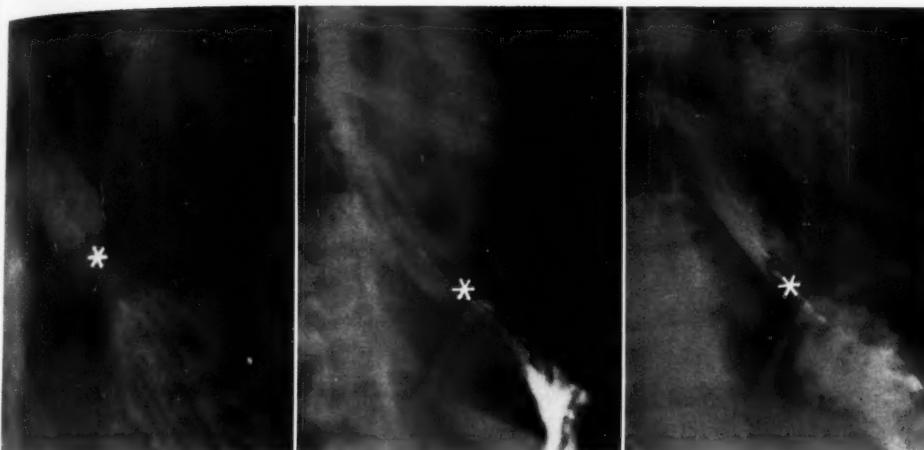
Relationship of PIP (star), as determined by intraluminal pressure tracings, to the roentgen appearance of the terminal esophagus and esophagogastric region in 3 normal cases during drinking of fluid barium. The patients are lying in the right anterior oblique position. No command to suspend respiration was given. PIP was located in each instance at the junction of the distensible region ("phrenic ampulla") with the narrowed segment. In other words, the ampulla is epiphrenic and the narrowed segment is intra-abdominal. The junction between these two regions is a roentgen landmark for PIP, *i.e.*, for the hiatus. The linear lucencies in the course of the esophagus are due to the indwelling polyethylene tubes.
